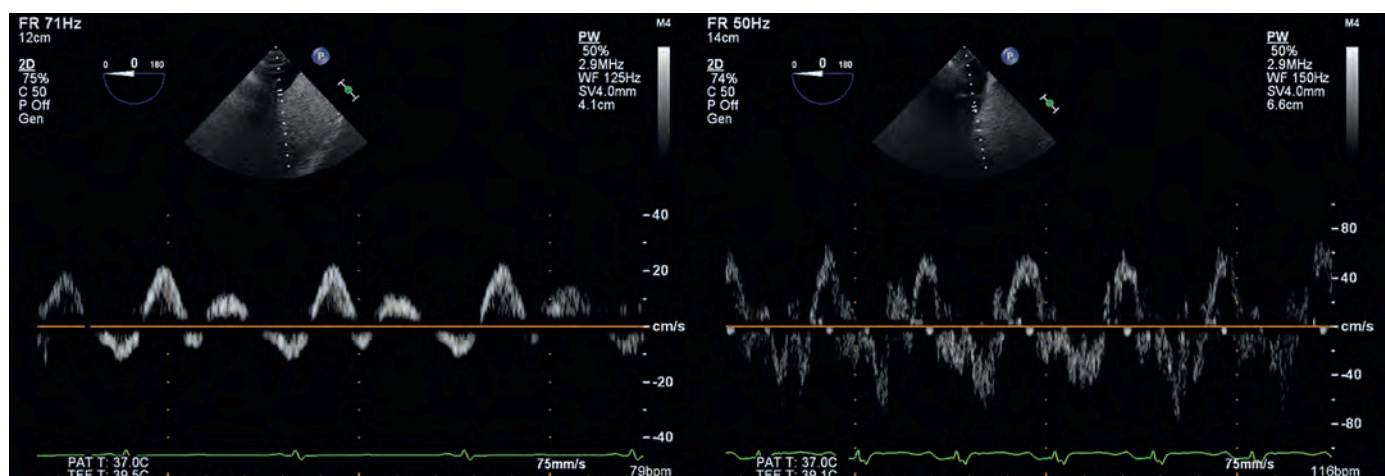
Hepatic venous flow. (Left) The normal hepatic venous Doppler spectrum reveals flow toward the right atrium during both systole and diastole. (Right) With severe tricuspid regurgitation, flow is away from the right atrium during systole.
